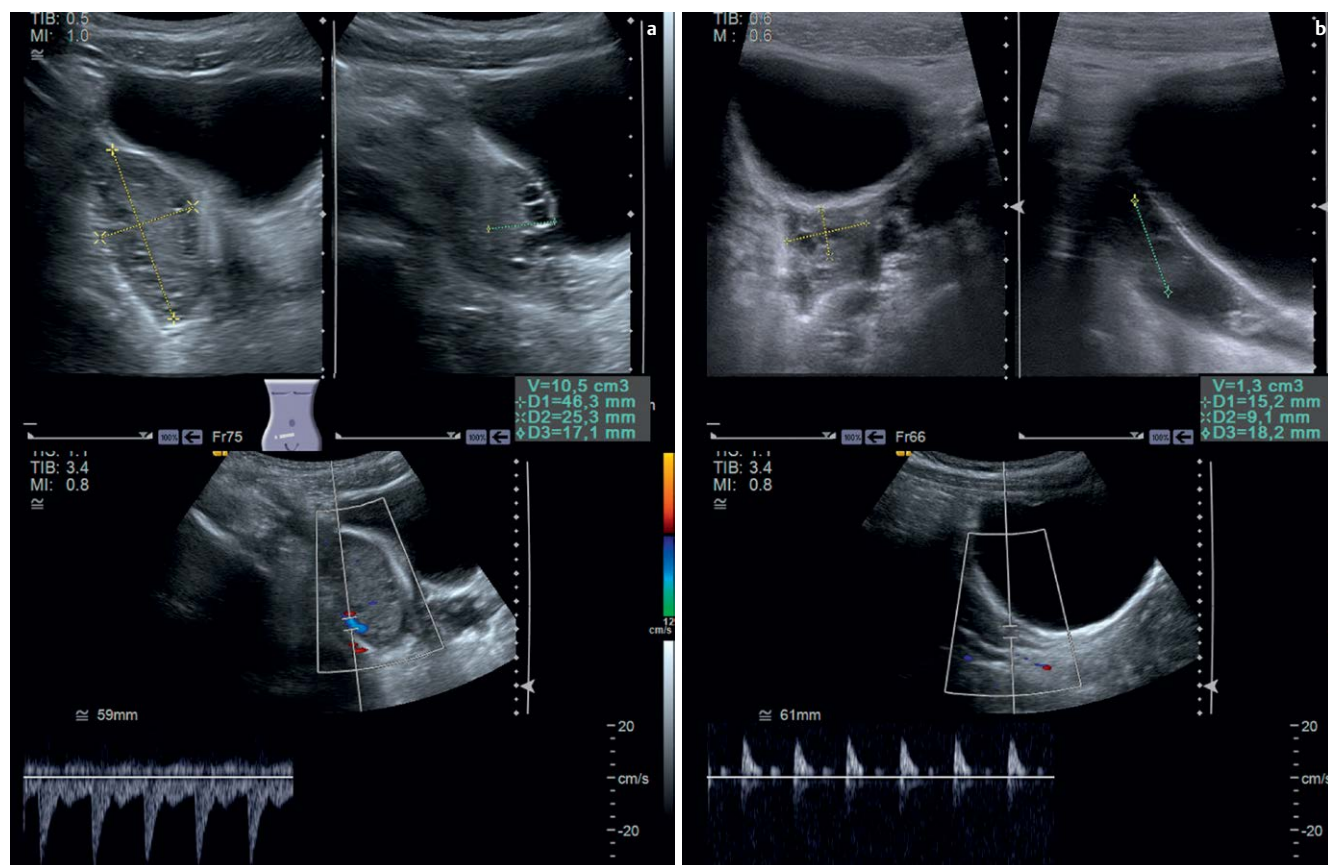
10-year-old girl with enlargement of the right ovary (volume of 10.5 ml) and multiple large follicles in the periphery. The Doppler flow pattern on the right side shows a positive diastolic flow consistent with a postpubertal flow pattern. b Normal left ovary (volume 1.3 ml). A Doppler pattern with no positive diastolic flow is typical in prepubertal girls.
